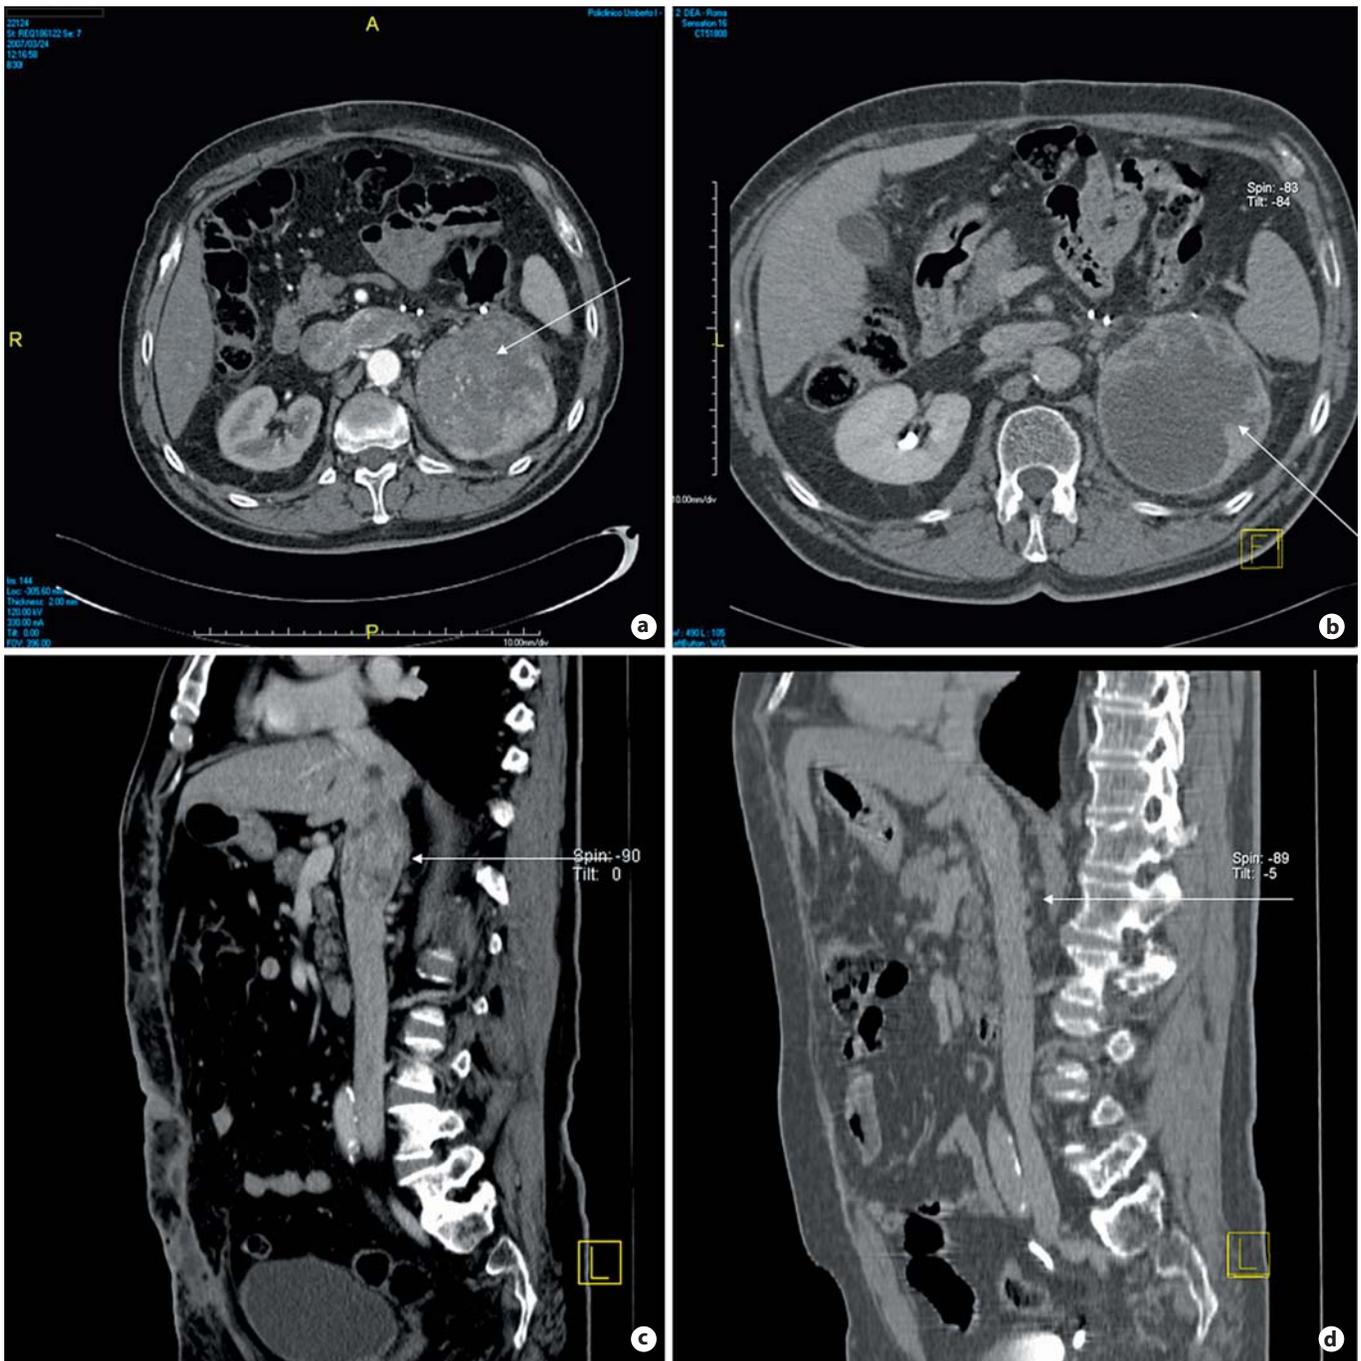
a Pretreatment (sorafenib) CT scan showing an 8.0-cm left-sided solid renal mass involving the upper pole and the medial aspect of the kidney. b Posttreatment (sorafenib) CT scan showing a 9.0-cm left-sided solid renal mass. c Pretreatment (sorafenib) CT scan showing a thrombus involving the left renal vein and the inferior vena cava. d Posttreatment (sorafenib) CT scan showing a thrombus limited to the left renal vein (no inferior vena cava involvement).
